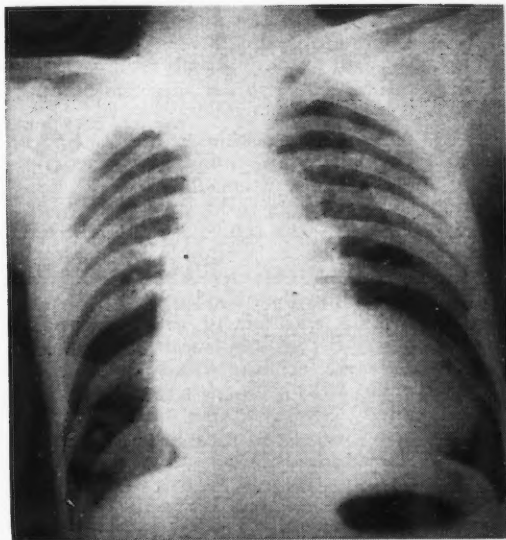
Radiographic appearance of chest showing large ventricular aneurysm.
